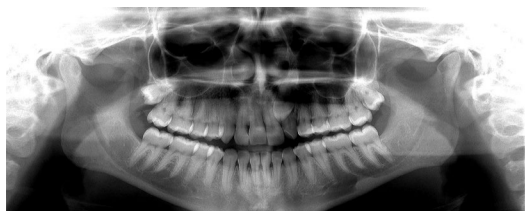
Panoramix x-rays: rotation, angulation, torque of central, lateral incisors and first premolars.
